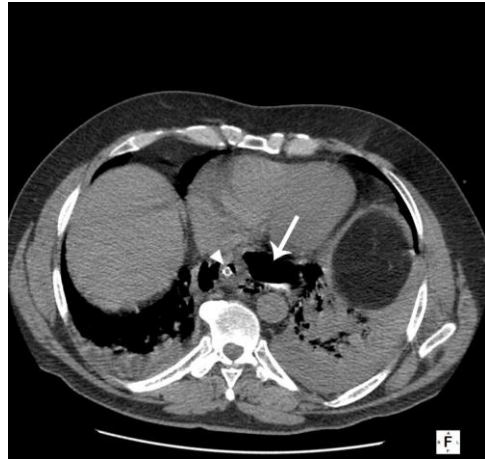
CT scan shows spontaneous rupture of distal oesophageal wall. Arrow indicates a fluid collection in the posterior mediastinum with an air-fluid level and presence of iodinated radiopaque contrast medium after oral administration.
